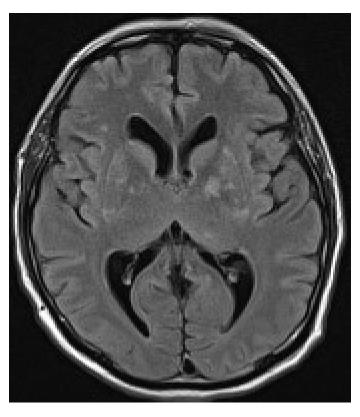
Nuclear magnetic resonance imaging performed on Day 5. Bilateral hyperintensities within the basal ganglia, the arteria cerebri media basin, and the central part of pons Varoli are apparent.
